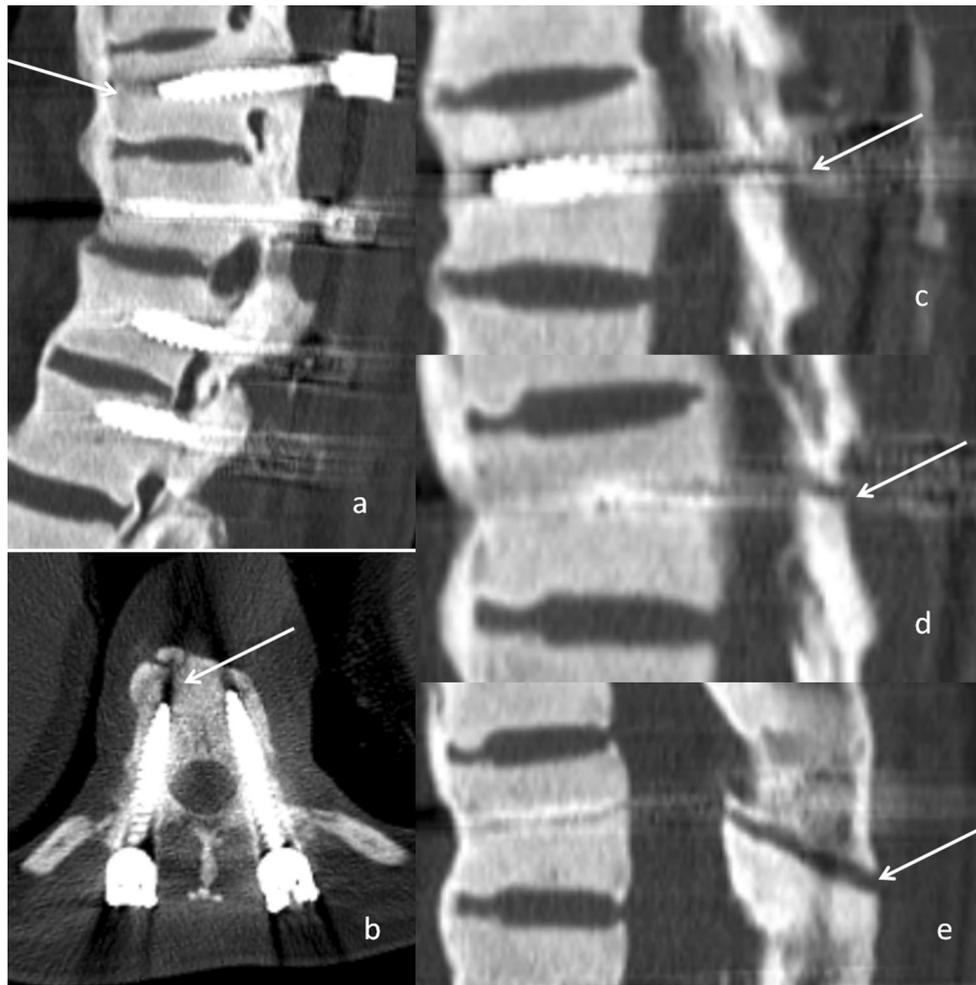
Post-operative CT scan performed at 4 weeks clearly shows a, b the fracture line extending along the screw tracts up to the anterior vertebral cortex marked by a *white arrow* at the upper instrumented level, c, d para-sagittal sections showing a fracture line in the lamina
